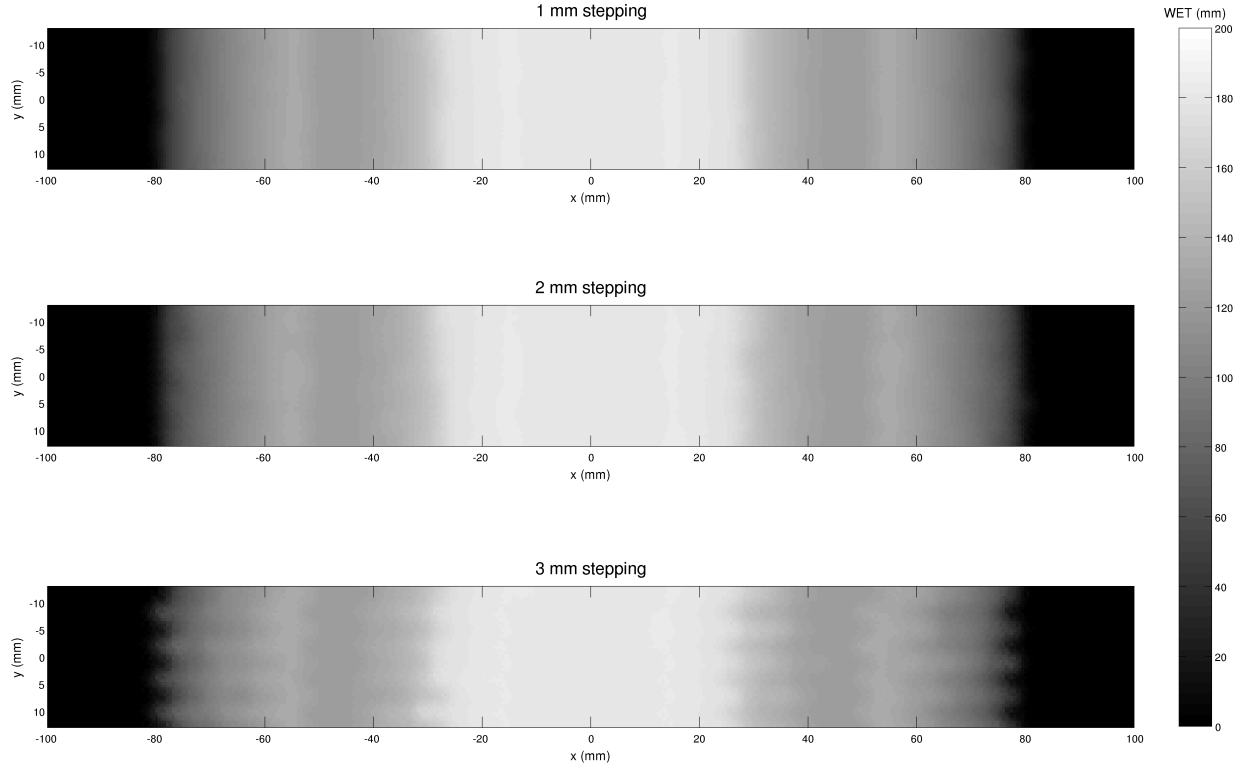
Comparison between the reconstructed radiographies with the new algorithm. The different lateral and vertical stepping used were 1 mm, 2 mm and 3 mm for the same low number of 100 ions per RP.
